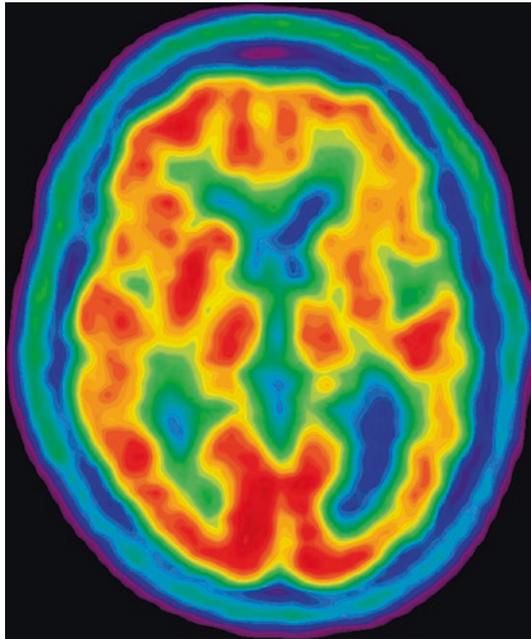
FDG-PET (*axial view*). Note subtle hypometabolism involving left anterior perisylvian (frontal opercular) areas
